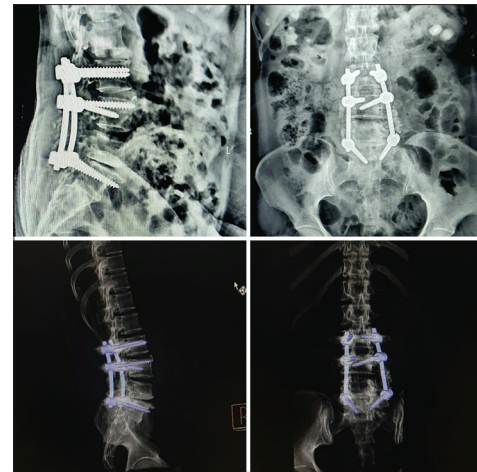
Post-operative X-rays and computed tomography cuts showing posterior instrumentation from L2 to L5 levels with correction of retrolisthesis of L3 over L4
